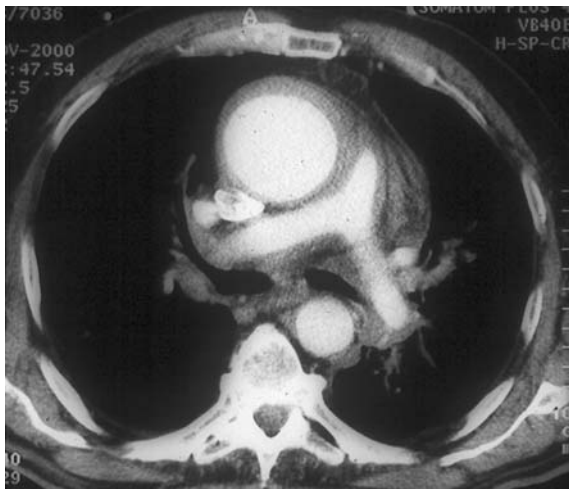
Computed tomography of a patient with an AAS who was first diagnosed of having an IAH, axial section. Notice a clear thickening of the wall of the ascending aorta. No entrance tear nor flow within the aortic wall could be detected
